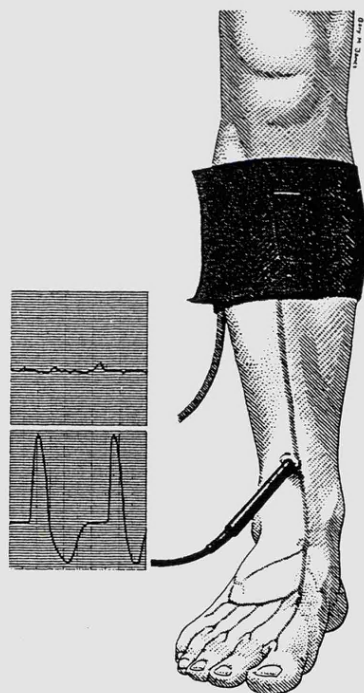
10 MHz Doppler probe insonating the anterior tibial artery. The top trace on the left shows a non-pulsatile signal at rest and on the right a biphasic waveform with the PGR system.
